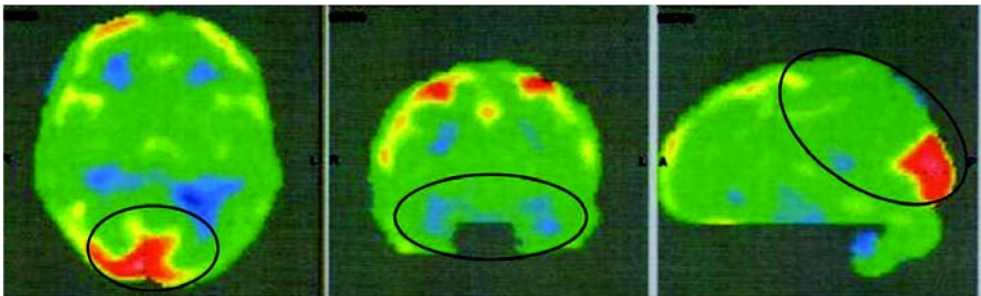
PET-CT scan after stem cell transplantation showing improved metabolism in bilateral occipital lobes mesial temporal structures
